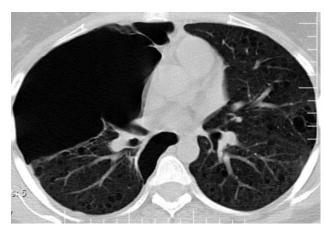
Computed tomography of pneumothorax in lymphangioleiomyomatosis
